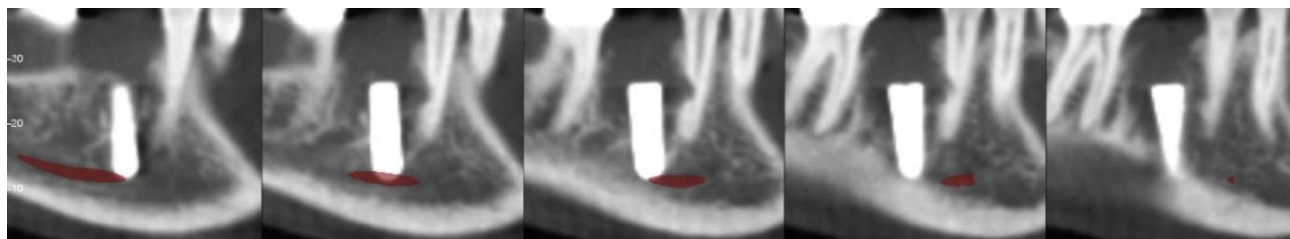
Cone beam images obtained 3 months after placement of an implant in a lower first molar site. The second bicuspid was sensitive to percussion
